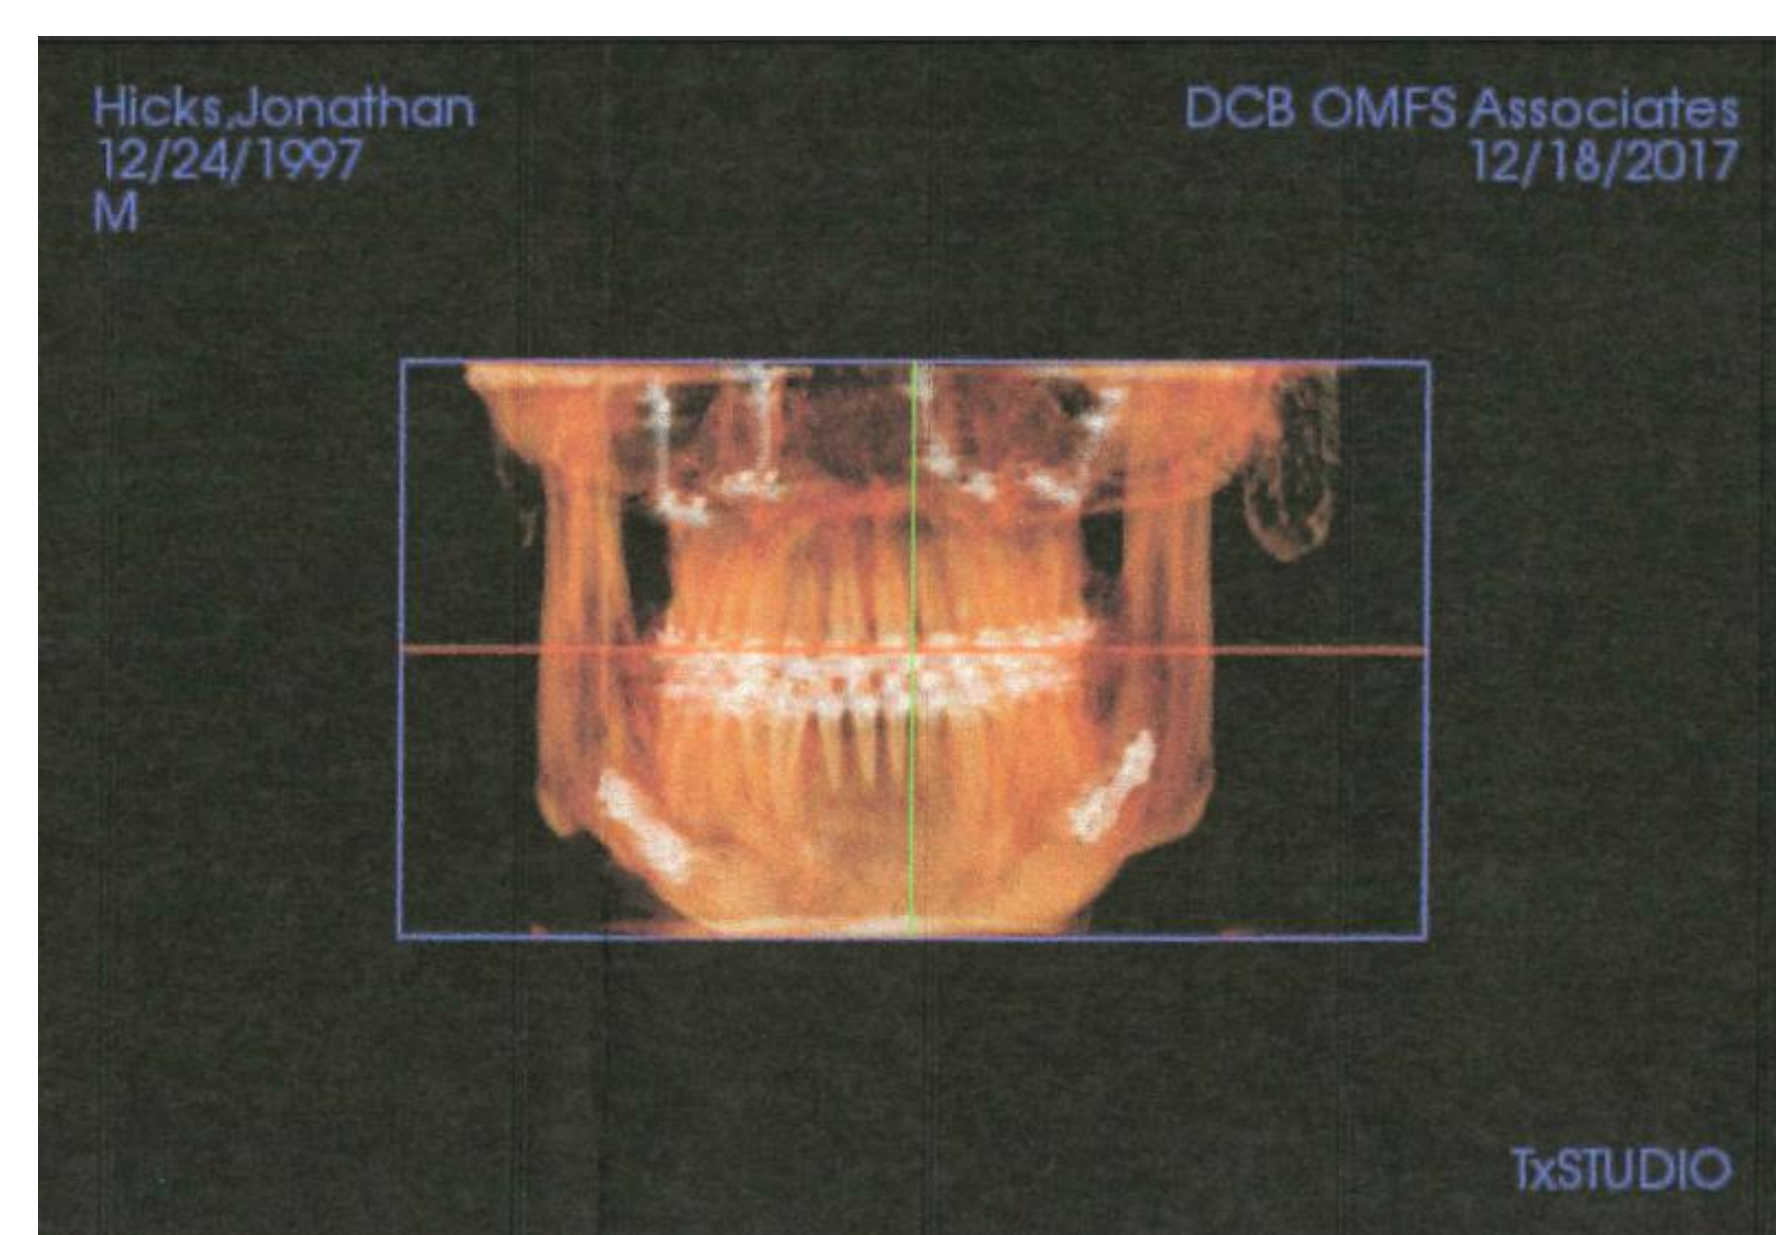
Example Maxillofacial Osteotomy CT scan
